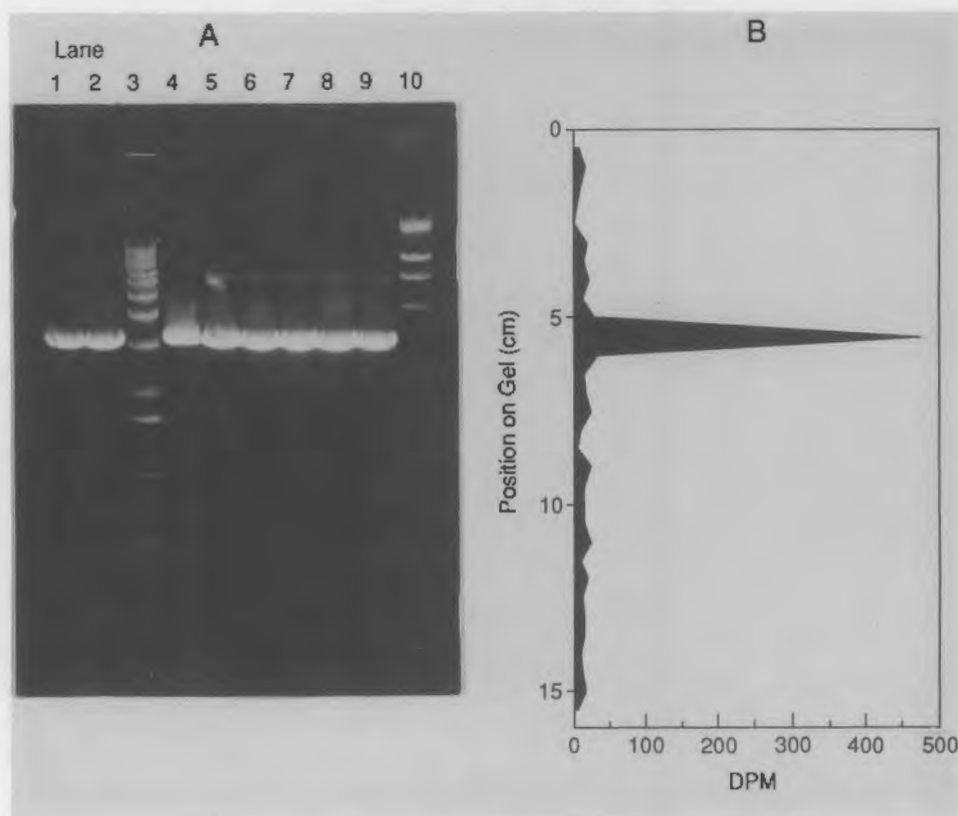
Photograph and Radiograph of Agarose Gel of pXP-14 Plasmid Demonstrates That Most (70%) of Adducted DNA Was Recovered After Incubation with Freshly Isolated Hepatocytes. In addition, 40% of radioactivity applied to gel co-purified with DNA. Lanes 1, 2, and 4 contain linearized plasmid; lane 3 contains DNA molecular weight ladder; lanes 5 to 9 contain plasmid adducted by [^3H]BaP metabolites produced by freshly isolated hepatocytes; lane 10 contains *Hind*III-digested lambda DNA as molecular weight markers. Large radioactivity peak at 5.5 cm (right) corresponds to bright band in photograph (left).
